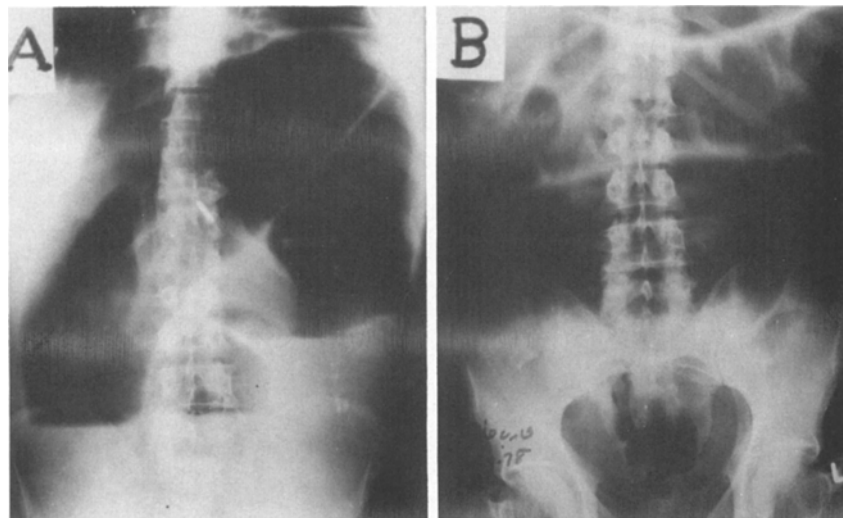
A. Erect plain x-ray of abdomen before detorsion. B. Same patient after detorsion showing rectal tube *in situ*.
